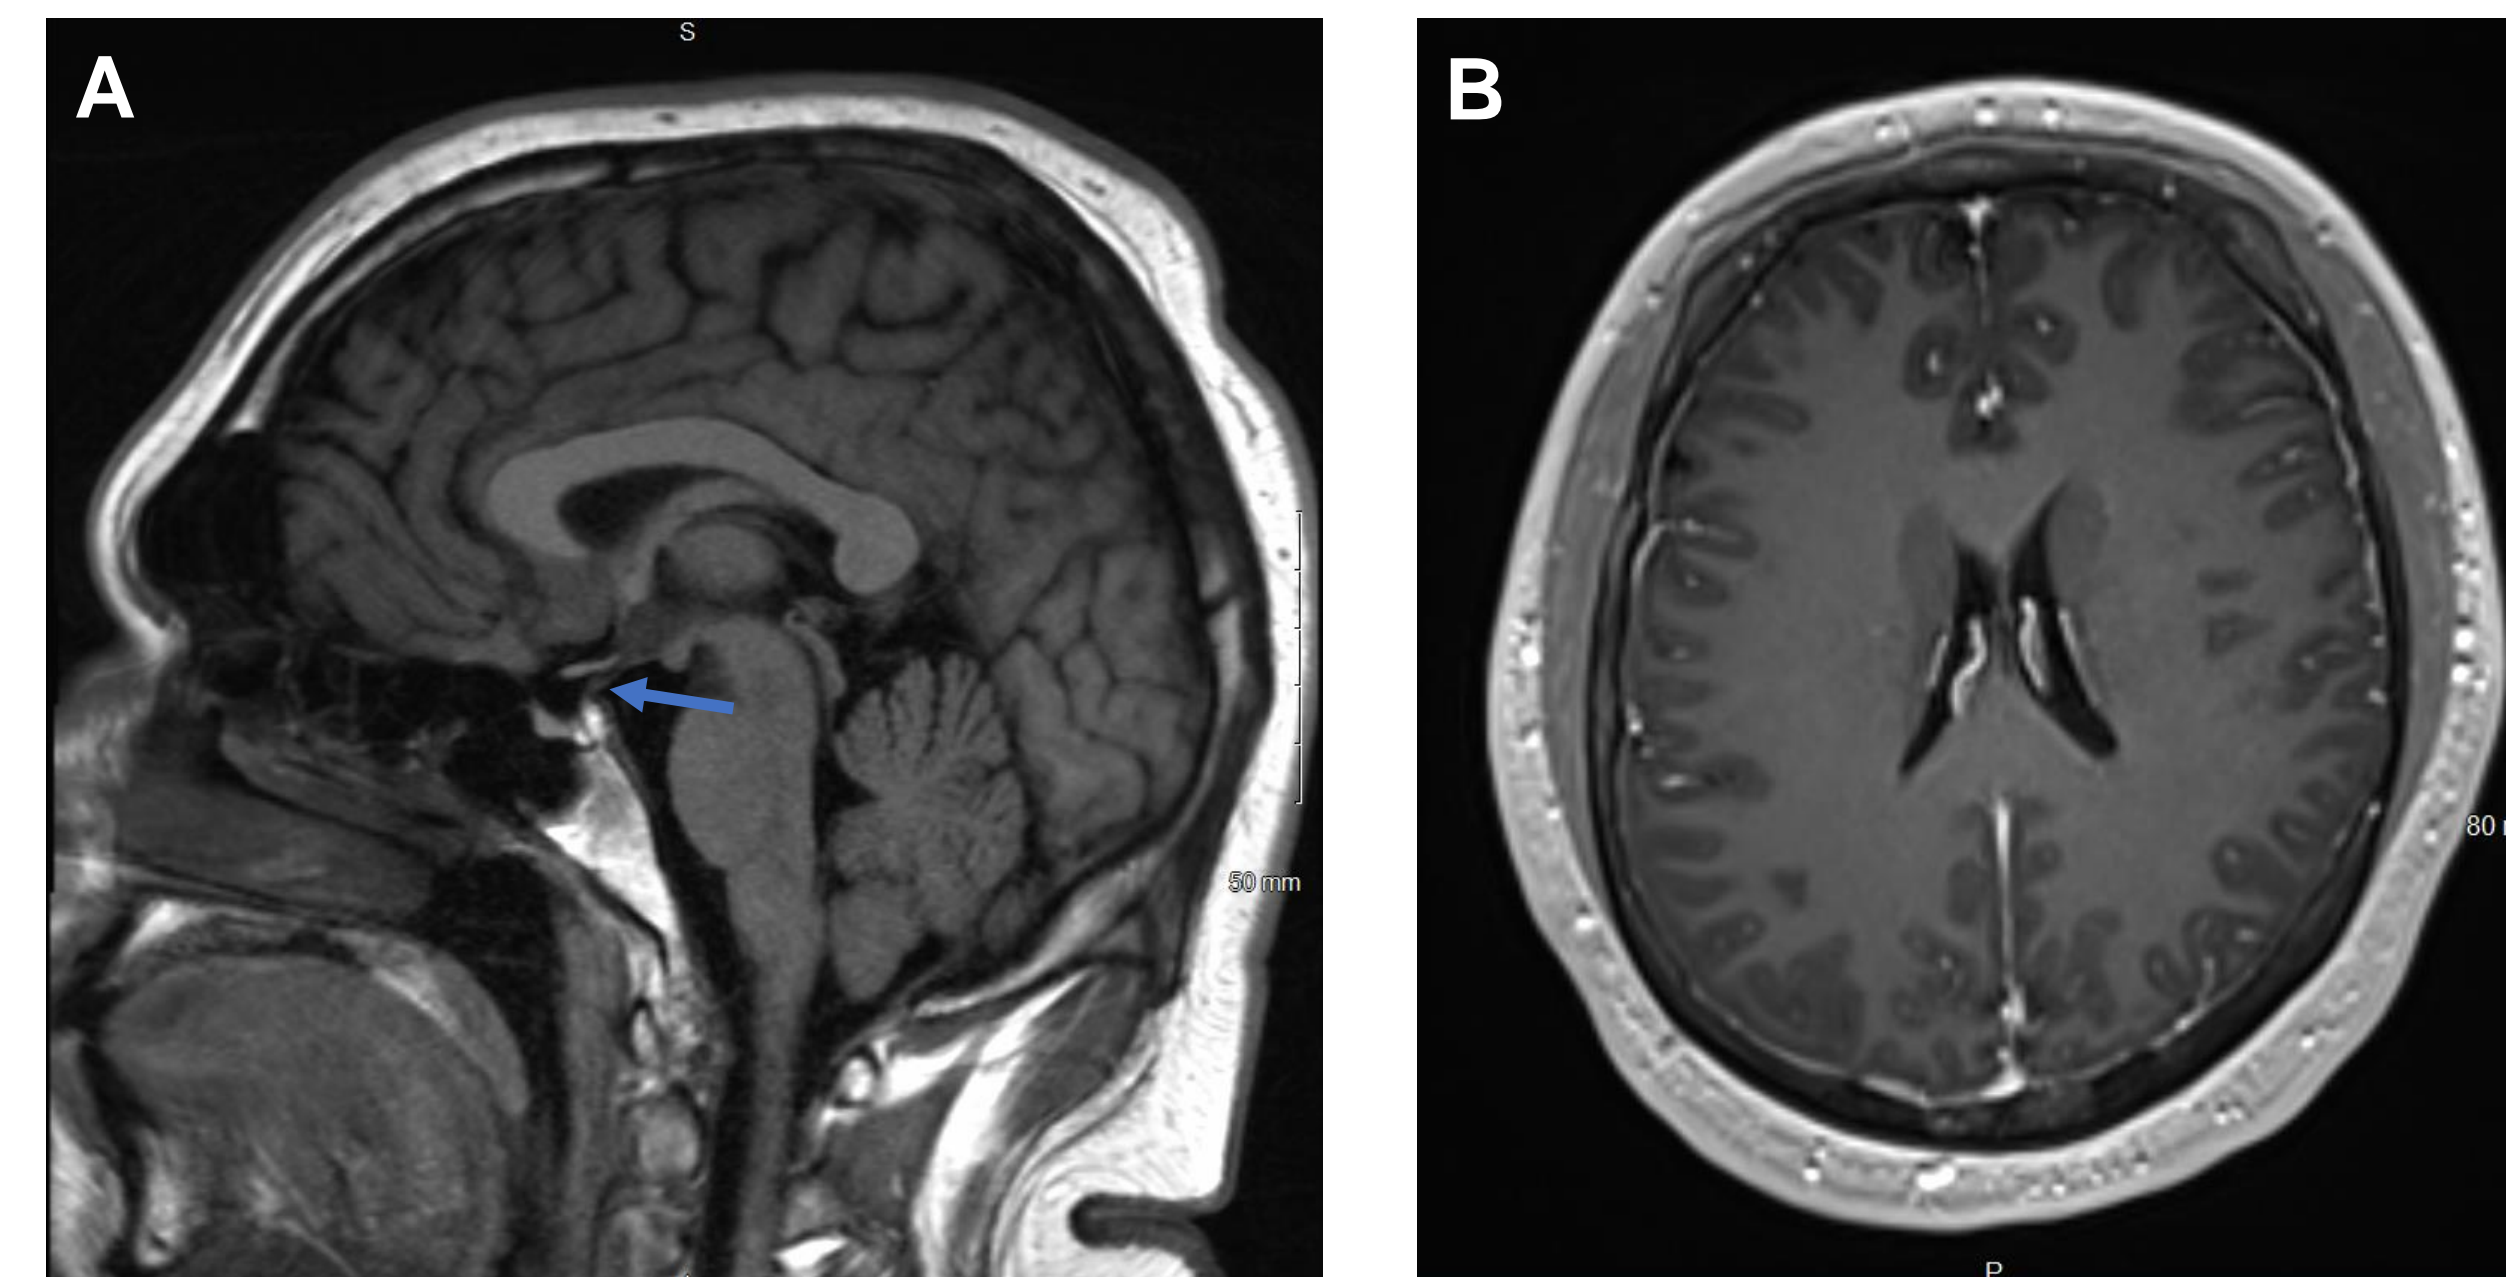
Brain MRI from 7 months prior. (A) Sagittal T1 FLAIR showing partially empty sella. (B) Axial enhanced 3D T1 FLAIR
